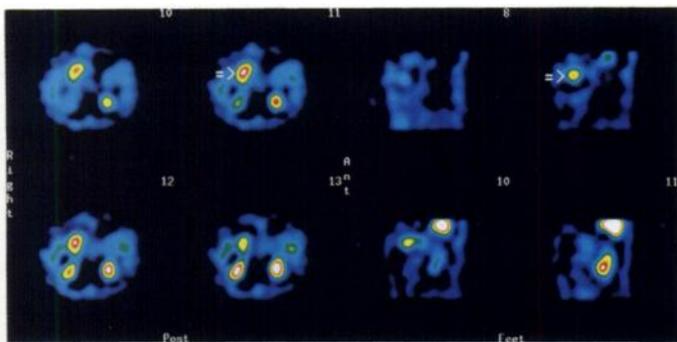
Recurrent adenocarcinoma (arrow) visualized by ^{123}I -VIP (Table 5, Patient 6). SPECT reconstruction (four transverse slices, left panel; four sagittal slices, right panel) identified the recurrent tumor at 3 hr postinjection in the transverse colon. In this patient, CT did not indicate tumor recurrence at the time of VIP receptor scanning. However, during the follow-up period, CT scan also indicated tumor mass at 8 wk after ^{123}I -VIP-injection. Indium-111-CYT-103 scintigraphy performed 4 wk after VIP receptor scanning gave negative results.
